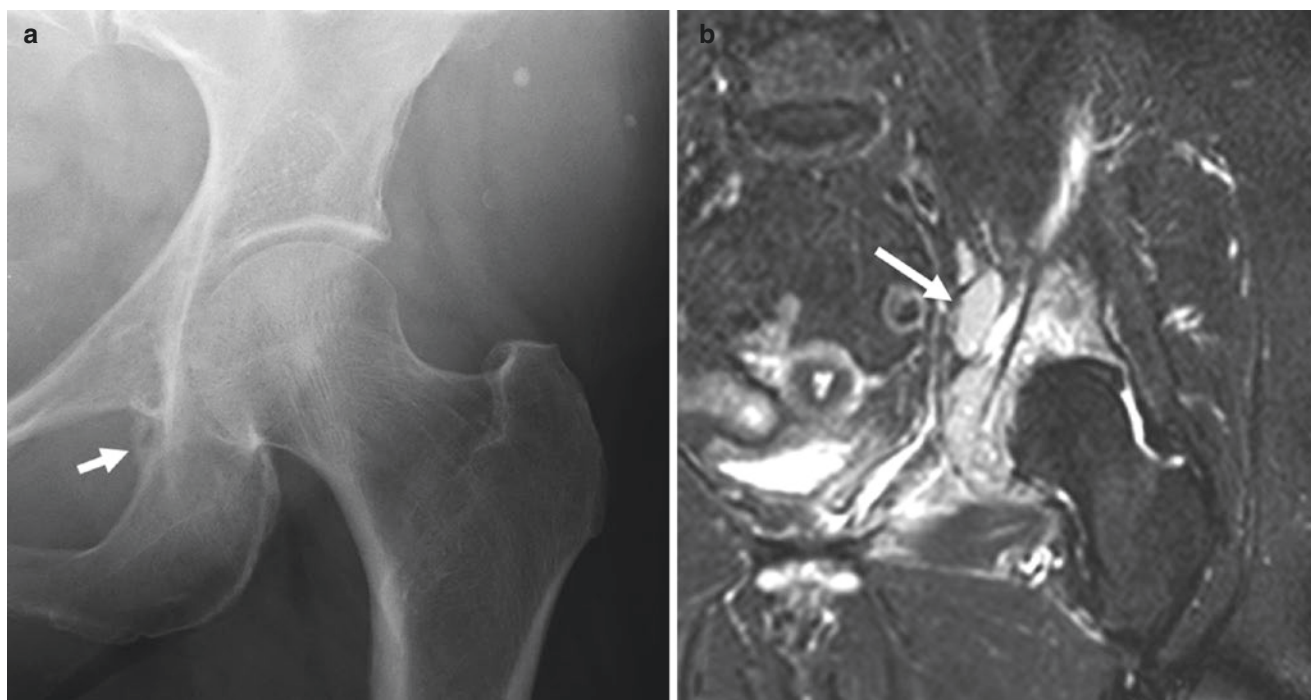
AP radiograph of the left hip demonstrates subtle periosteal reaction along the medial margin of the ischium (a—arrow). The subsequent coronal STIR MR image demonstrates a large marrow-replacing mass in the left acetabulum with soft tissue extension and an enlarged
